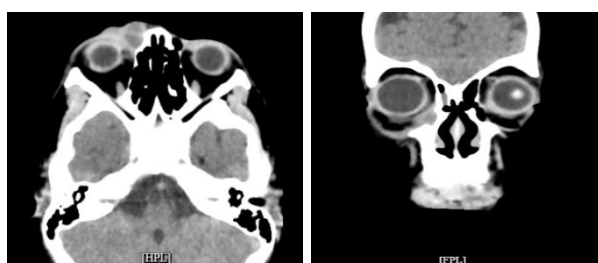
Contrast orbital CT scan of patient K.
